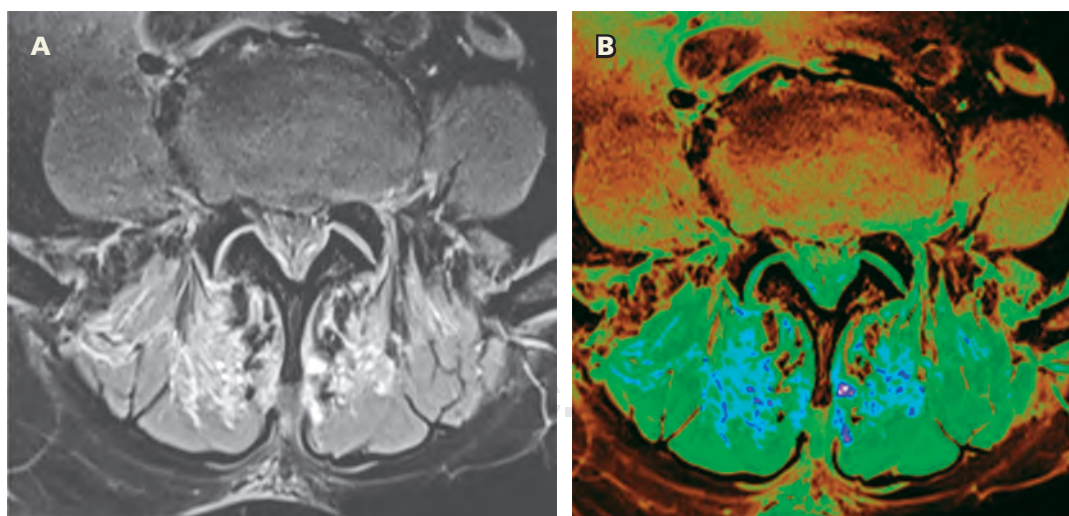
71-year-old man with SARS-CoV-2. A) Fat-suppressed contrast enhanced T1-weighted axial MR image and B) color map, shows a reliable increase in the volumen and size of the intrinsic muscles of the lumbosacral region. Also, asymmetric bulging of the intervertebral disc can be observed.
